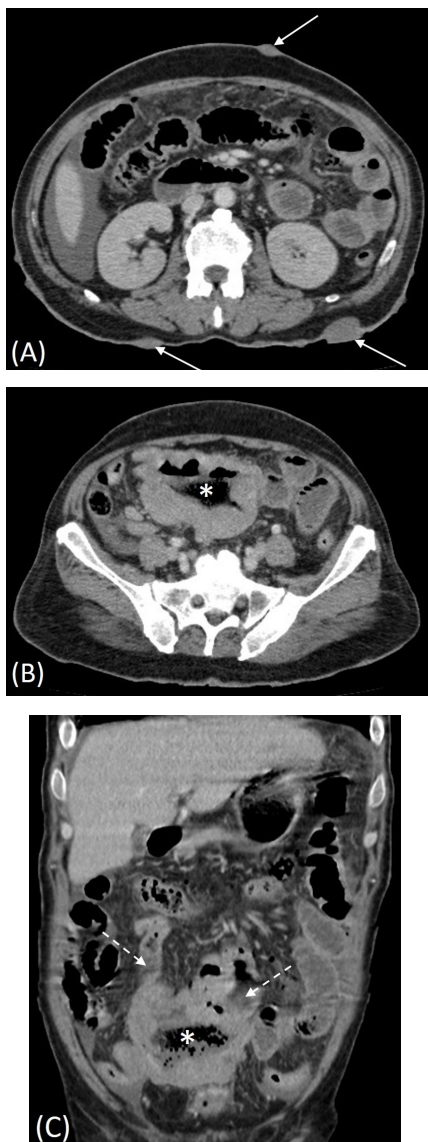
Axial (A and B) and (C) coronal sections of the patient's CT of the abdomen and pelvis obtained on the same day following the abdominal radiograph.
